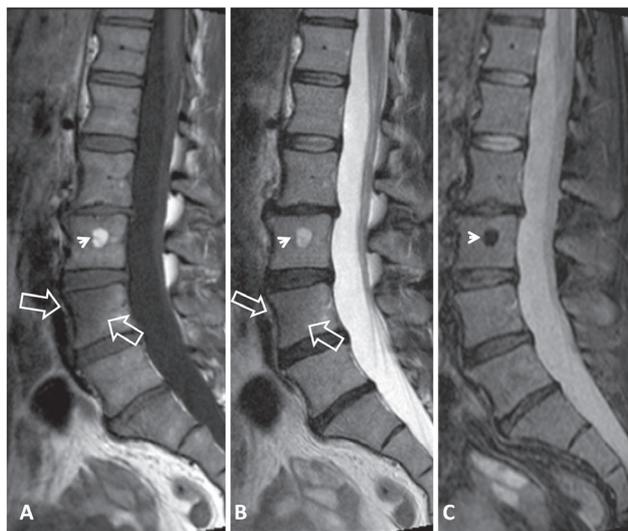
A 47-year-old female patient with primary non-Hodgkin lymphoma of the spine. Sagittal MRI shows a low signal intensity lesion in the L4 vertebral body (open arrows) on the T1w image (A). The lesion returns a low signal on the corresponding T2w image (open arrows) (B) and remains occult on the STIR image (C). A fatty island of no clinical significance is shown in the L3 vertebral body (arrowheads).
